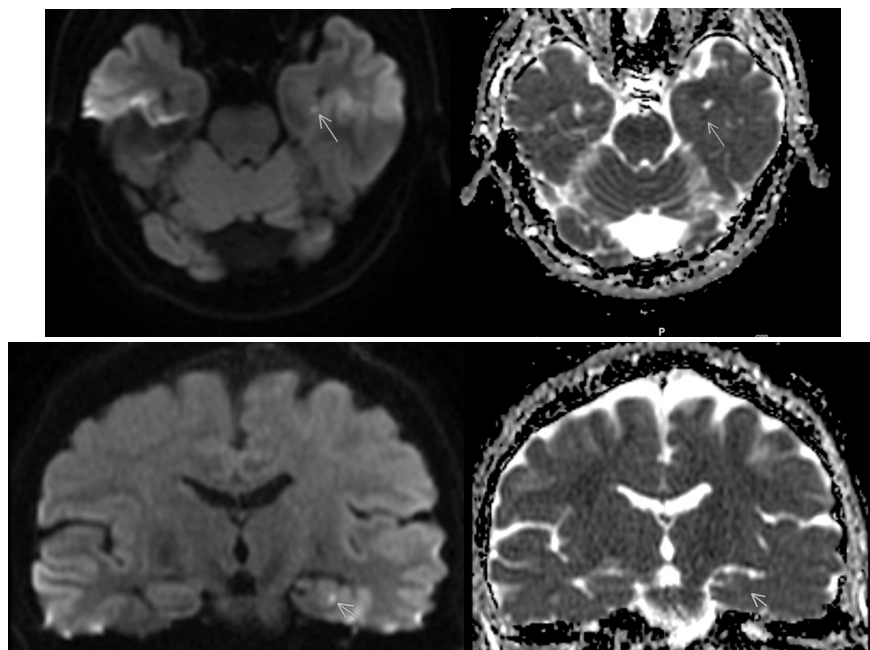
Representative 1.5T MRI of a patient shown a single punctuate lesion on diffusion weighted imaging with a corresponding low signal on the apparent diffusion coefficient map (green arrow) in the axial and coronal planes. (Front cover page)
